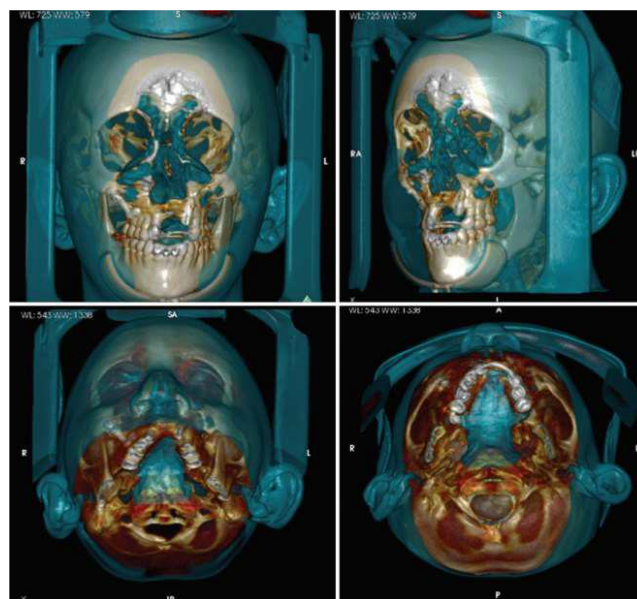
CBCT of cleft lip and palate
